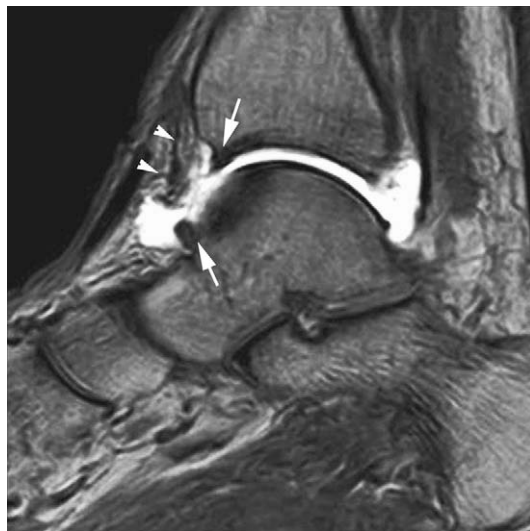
Anterior impingement syndrome. Sagittal T1-weighted spin echo MR arthrogram of right ankle shows anterior tibial and talar osteophytes (“kissing lesion”) (arrows), and irregular soft tissue mass in the anterior capsular recess (arrowheads).
